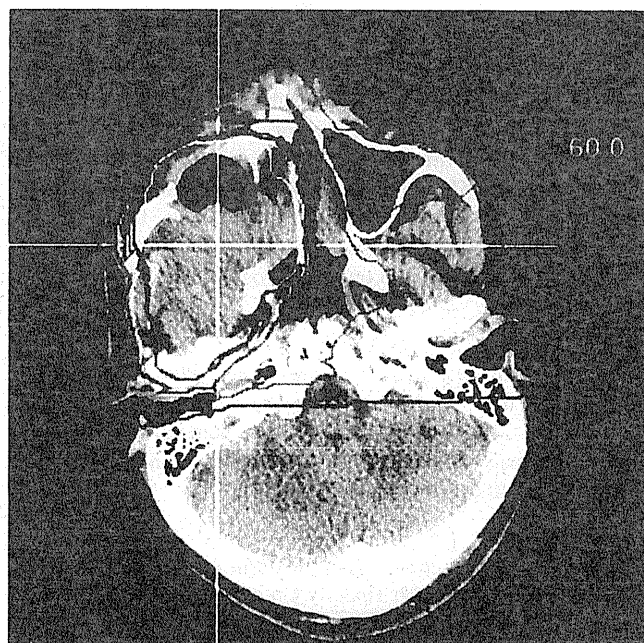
Dose distribution on the computed tomography image for treatment planning. Isodose lines indicating 95%, 90%, 70%, 60%, 50%, 30%, and 10% dose areas (from inside to outside).
